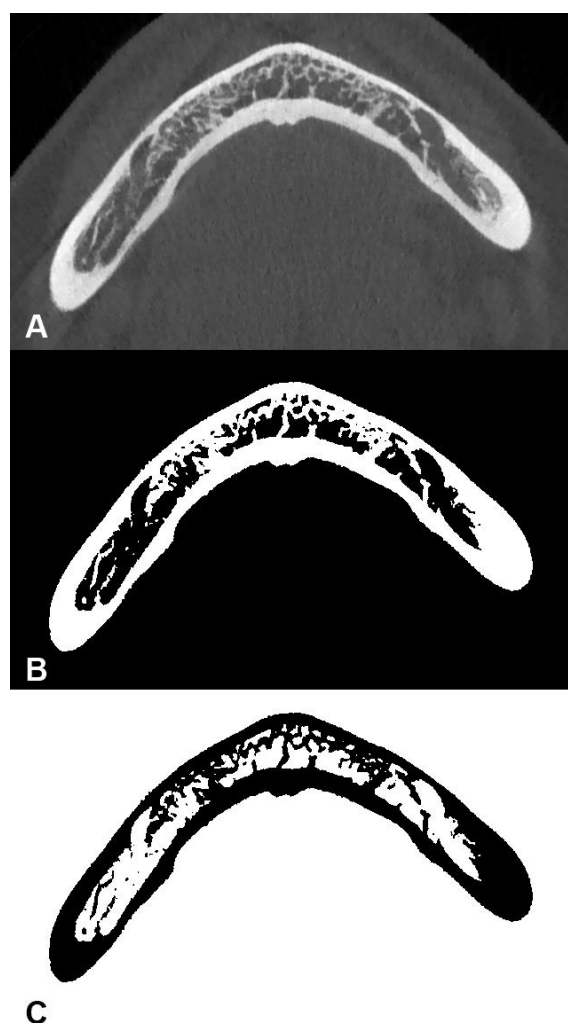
Computed tomography image of the mandible and its segmentation:
